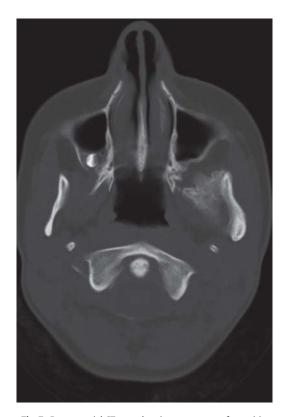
Post-op axial CT scan showing recurrence of myositis.
